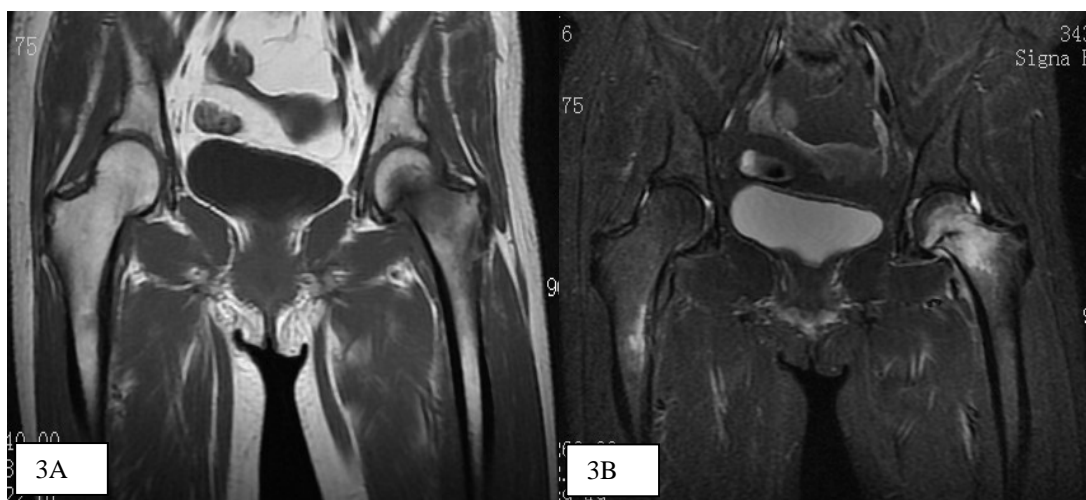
A) T1-weighted magnetic resonance image (MRI) showing a large low-intensity area in the left femoral head (FH) and femoral neck (FN) and an occult insufficiency fracture of the left FN; B) T2-weighted MRI showing a large area of bone marrow edema in the left FH and FN and an occult insufficiency fracture of the left FN.
